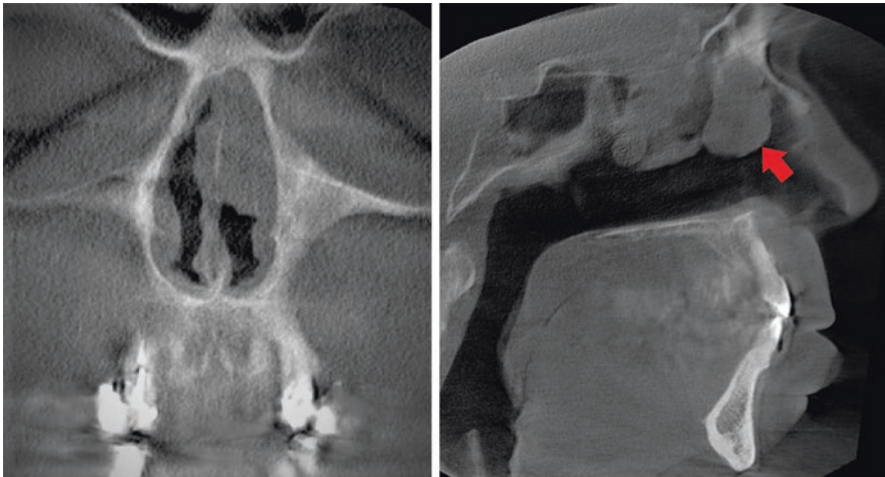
Coronal and sagittal CBCT views of a soft tissue mass in the left nasal cavity. When reviewing the scan in the coronal plane, the identification of the normal anatomy of the turbinate and meatus is key to detecting these lesions, especially when small. The sagittal view demonstrates the morphology of this lesion (arrow)
